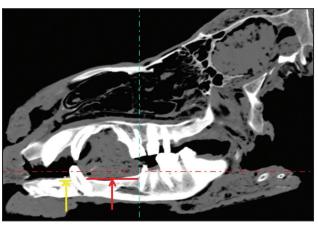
Sagittal plane of CT showing short cranial interdental space (yellow arrow) than caudal interdental space (red arrow).
